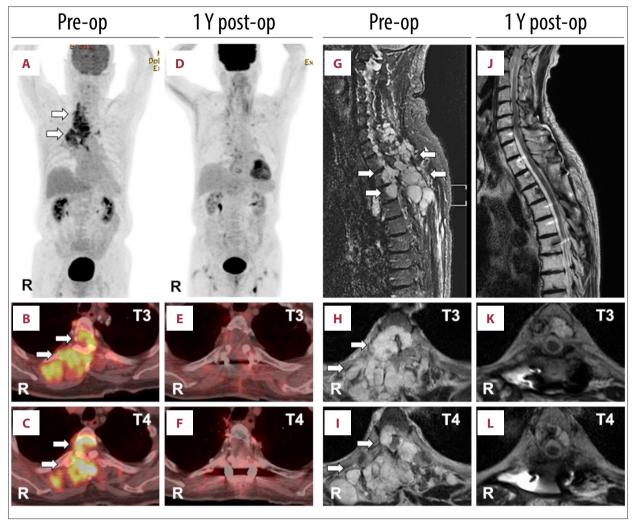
Comparison of preoperative and one-year postoperative images showing no local recurrence of the tumor. (A-C) Preoperative positron emission tomography (PET) images of coronal (A) and axial at T3 (B) and T4 (C) sections. (D-F). One-year postoperative PET images of coronal (D) and axial at T3 (E) and T4 (F) sections. (G-I) Preoperative T2-weighted magnetic resonance images (MRI) of sagittal (G) and axial at T3 (H) and T4 (I) sections. One-year postoperative T2-weighted MRI of sagittal (J) and axial at T3 (K) and T4 (L) sections. White arrows indicate the tumor.
